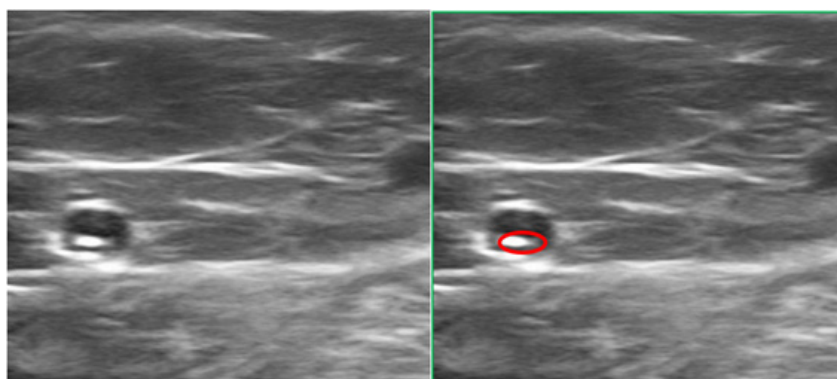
Cross-sectional ultrasound image. Intra-fascial Greater Saphenous Vein, showing Arrow catheter tip.
